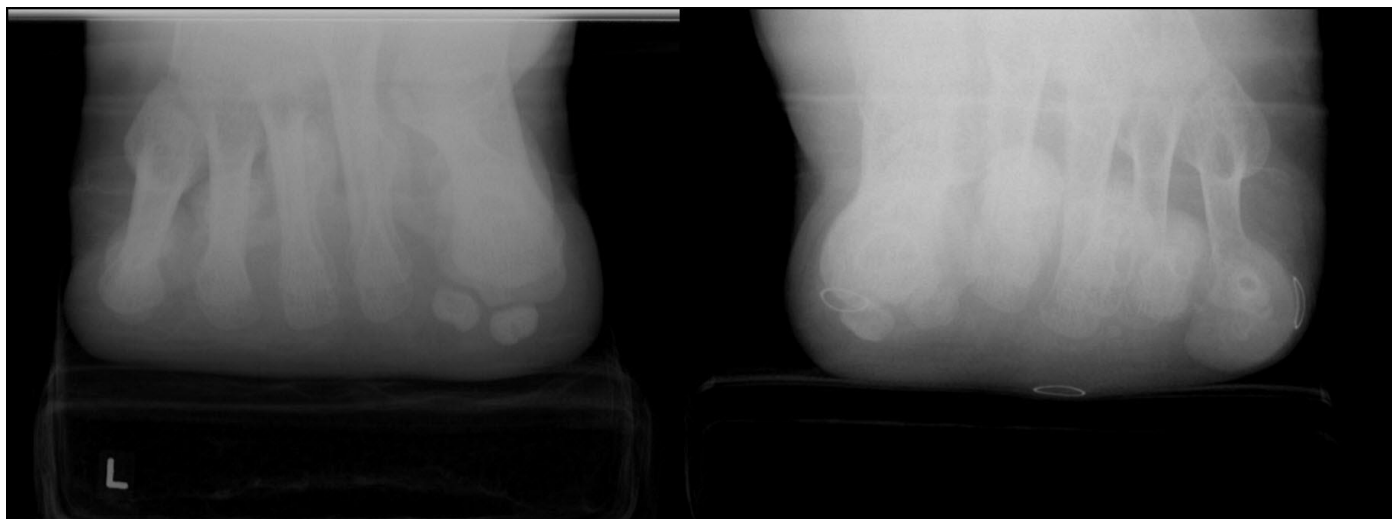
These are two sesamoid axial radiographic projections are used to more specifically assess the plantarflexion of the metatarsal heads during gait. The left image demonstrates metatarsals which all fall on a relatively straight line in this view. The right image demonstrates a third metatarsal head which is extending further plantarly than the adjacent second and fourth metatarsal heads. A marker also corresponds to this area, where there was localized pain and tenderness.
